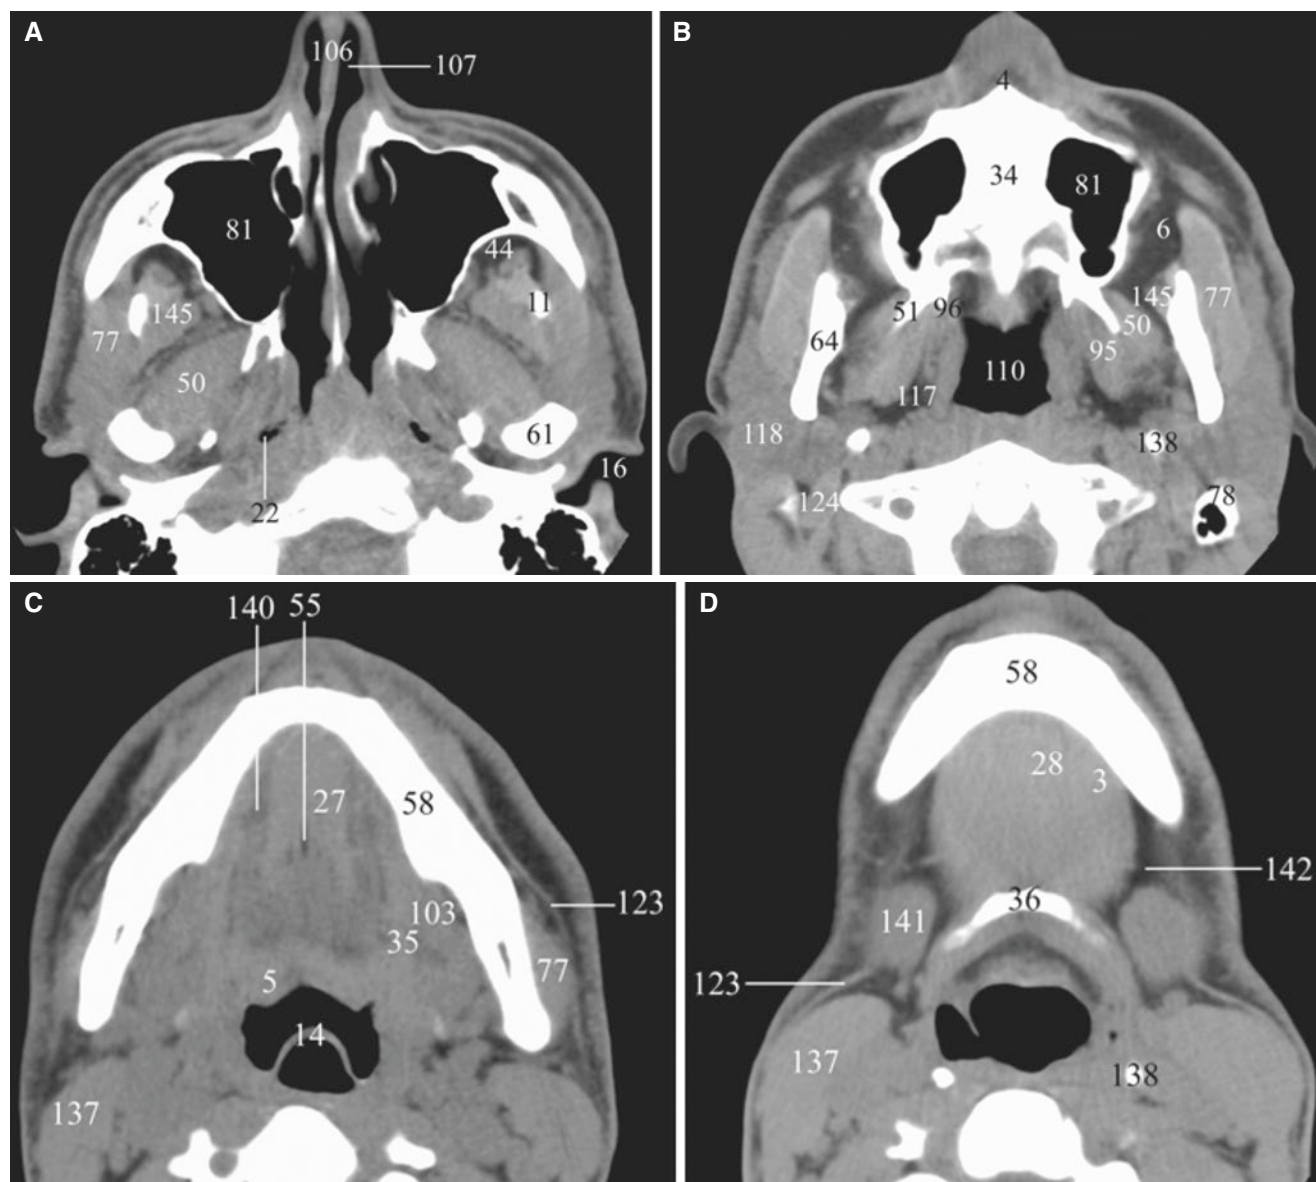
Normal soft-tissue anatomy of the face; axial CT images from superior (A) to inferior (D)
